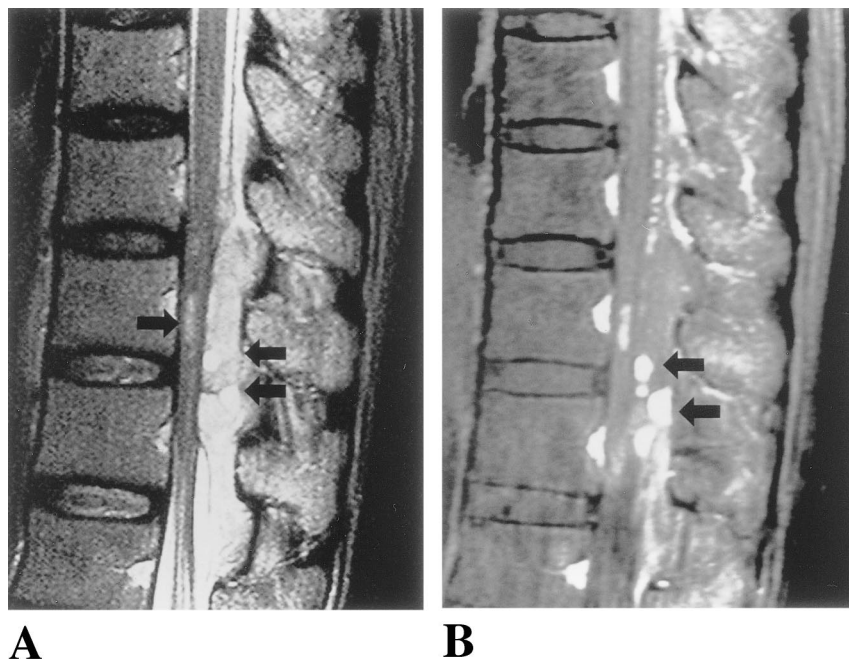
A, Sagittal T2-weighted image, obtained 5 hours after the onset of symptoms, showing an inhomogeneous epidural mass (double arrow) compressing the spinal cord. In the center of the spinal cord, slit-like hyperintensity (arrow) is noted.
